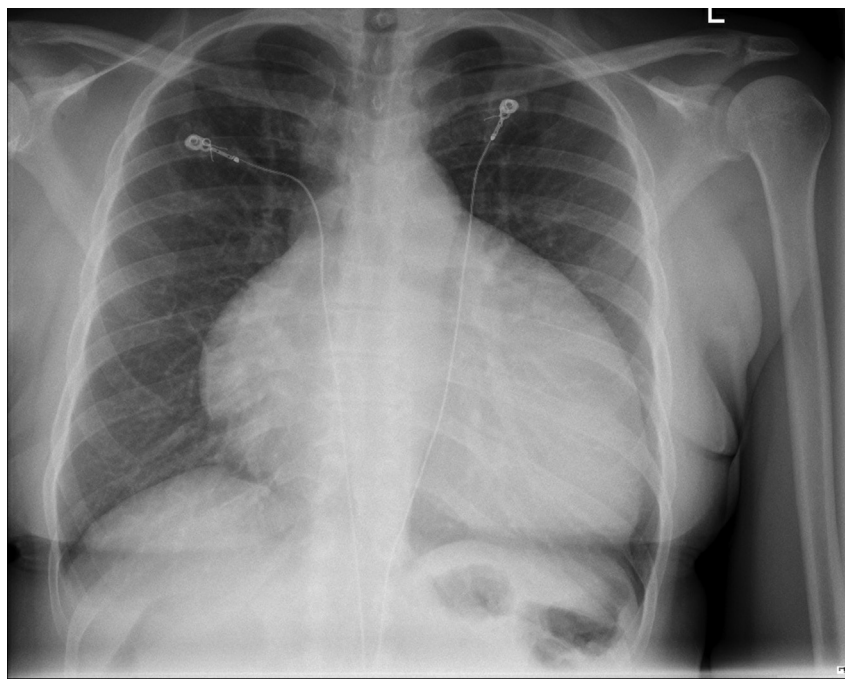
Chest Xray showing markedly enlarged heart.
